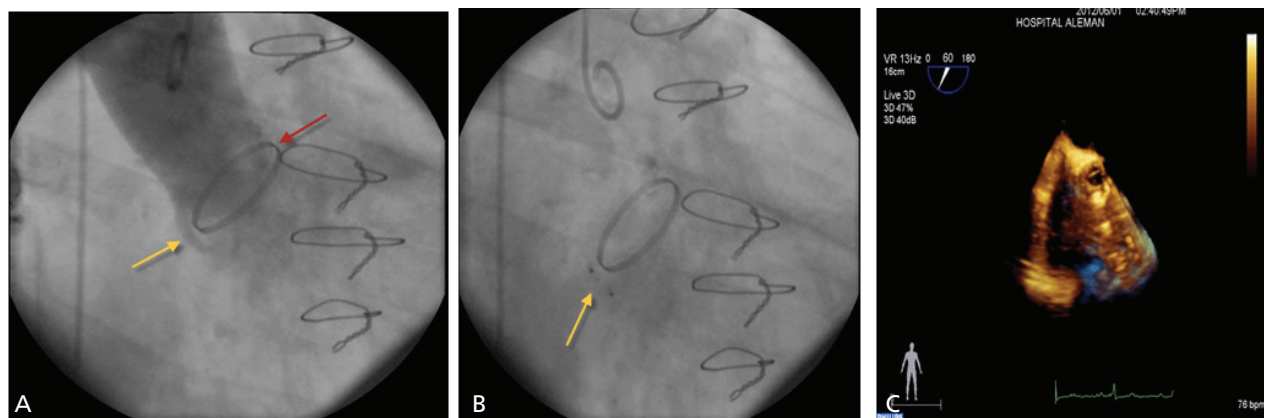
Aortic paravalvular leak. A. Angiography showing the prosthesis in the aortic position and the paravalvular leak. B and C. Angiography and 3D-transesophageal echocardiography of the deployed Amplatzer Vascular Plug II ® occluding the paravalvular leak trajectory (arrows).
